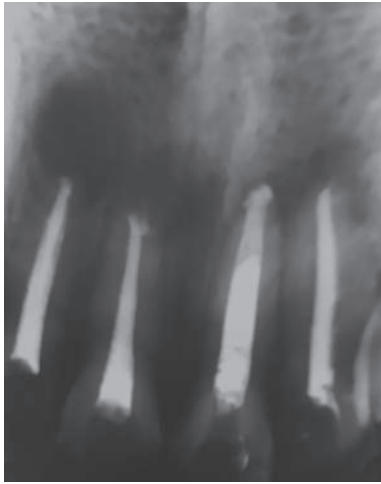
Postsurgical IOPA radiograph
